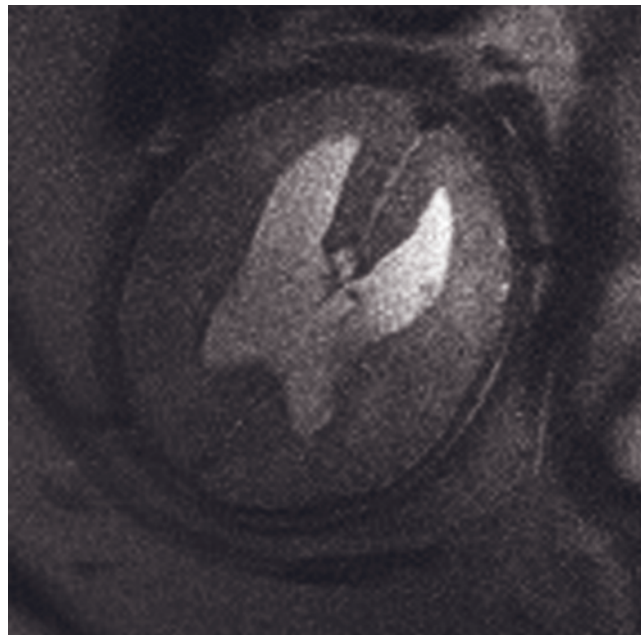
Myelomeningocele and Chiari II malformation. T1-/T2-weighted steady-state free-precession images in the sagittal (*a*) and transverse (*b*) planes show a 3.7-cm myelomeningocele extending from the lumbar spinal canal. Linear hypointensities seen in the sagittal plane are consistent with nerve roots (arrows, *a*). Flow-related artifact on T2-weighted SS-ETSE images (*c*) precluded confident identification of the nerve roots with this sequence (compare *c* to *b*). Sagittal T1-/T2-weighted steady-state free-precession image of the brain (*d*) shows Chiari II malformation, with herniation of cerebellar tonsils through an enlarged foramen magnum and a small posterior fossa. Transverse T2-weighted SS-ETSE image (*e*) demonstrates ventriculomegaly, with the lateral ventricles measuring 2 cm at the atria.
